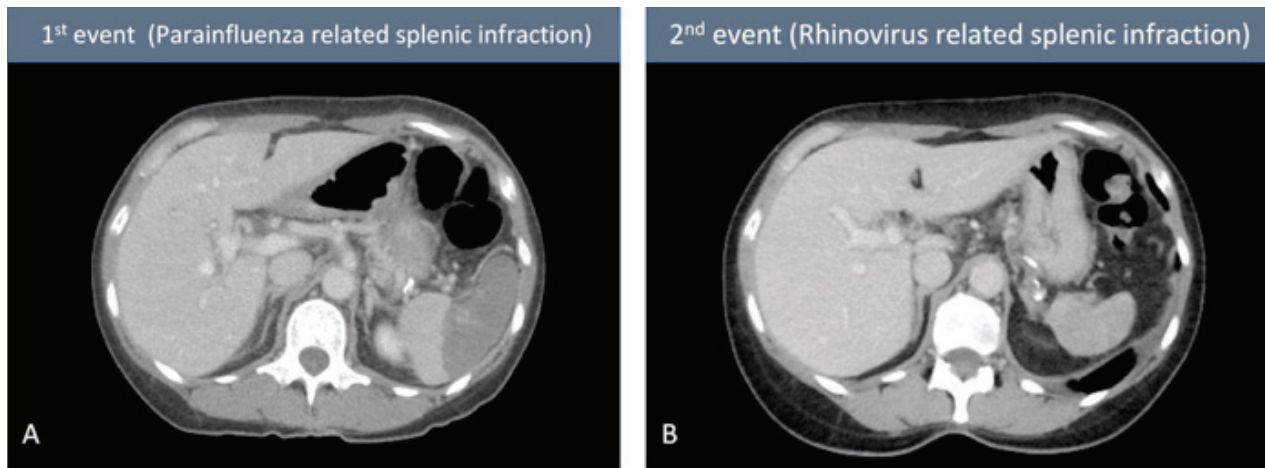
A) CT scan of abdomen and pelvis with contrast showing a wedge-shaped hypoattenuation of approximately 50% of the anterior aspect of the spleen suggesting splenic infarction; B) CT scan of abdomen and pelvis with contrast suggesting shrinkage of the spleen with small residual hypodensities peripherally. There is evidence of a new thrombosis of the splenic artery suggesting an evolution of new infarction.
